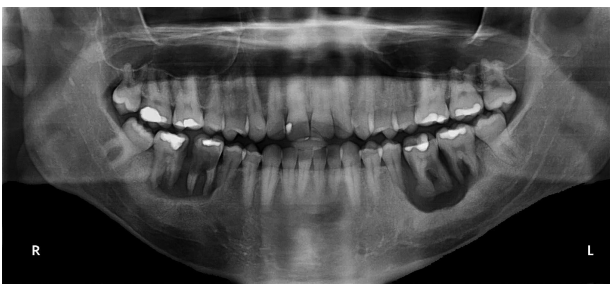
Panoramic x-ray showing two symmetrical radiolucent lesions involving the roots of the lower molars.
